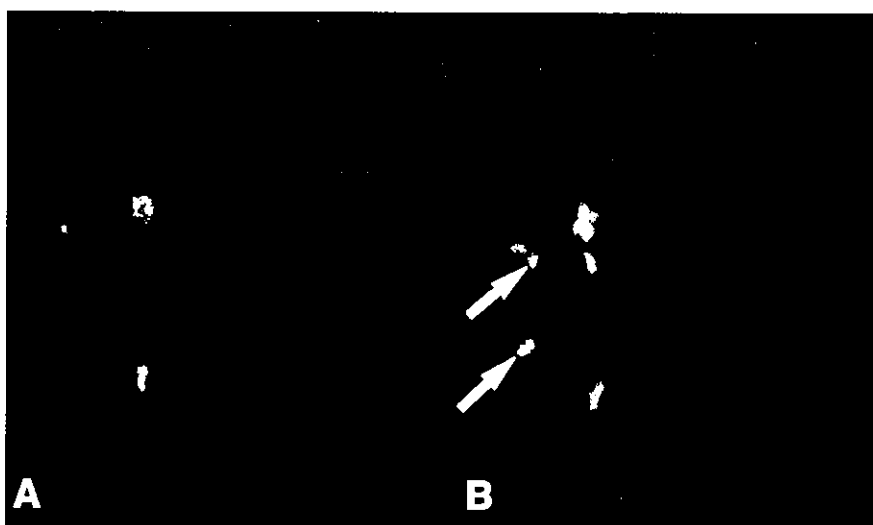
A 78-year-old man presented with left hemiparesis and unilateral spatial neglect (USN). NIHSS score on admission was 6. Color-flow duplex carotid ultrasonography showed 90% stenosis in the right internal carotid artery. Diffusion-weighted imaging (DWI) on day 2 demonstrated acute small multiple ischemic lesions in the right hemisphere (A). He had stepwise deterioration with left sensory disturbance and hemiparesis from days 3 to 7. The NIHSS score increased from 4 (day 3) to 9 (day 7). Follow-up DWI on day 8 revealed additional acute ischemic lesions (B, arrows).
